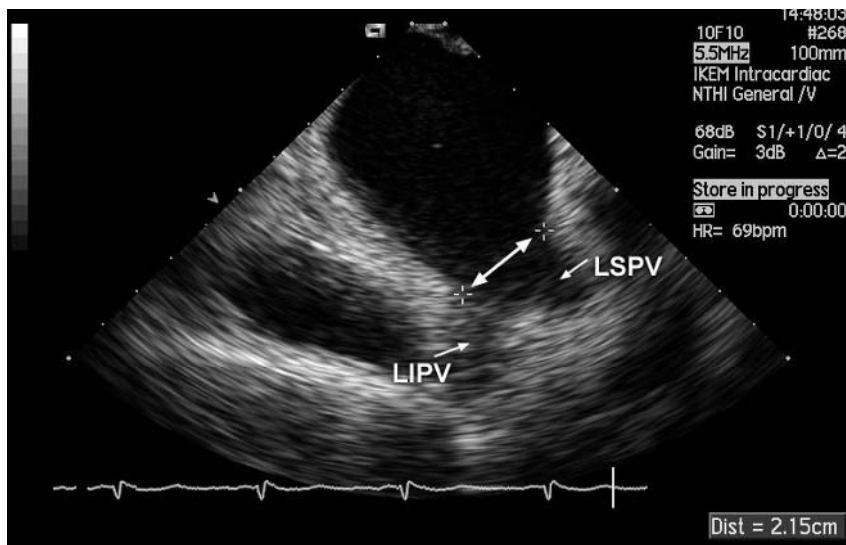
Common vestibule of the left-sided pulmonary veins (*doubleheaded arrows*) as depicted by intracardiac ultrasound (ACUSON, Siemens, Mountain View, Calif., USA). *LIPV* left inferior pulmonary vein, *LSPV* left superior pulmonary vein
